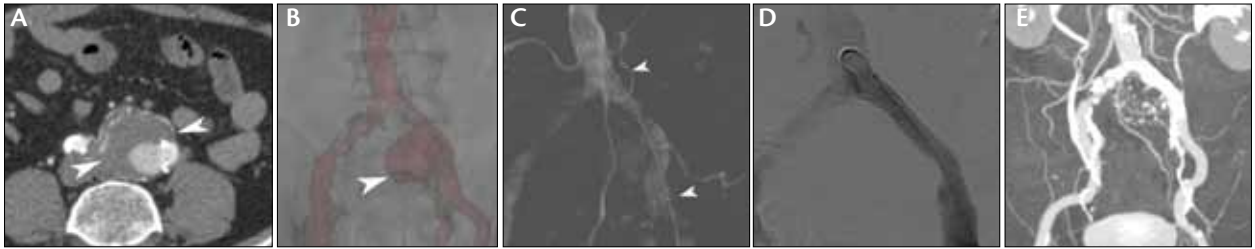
Axial CT image (A) showing an aneurysm of the left CIA (arrowheads). Note interruption of the calcific rim medially, indicative of a penetrating ulcer. Fusion image of live fluoroscopy and imported CT data showing the aneurysm (arrowhead) (B). Roadmap image showing position of the stent (arrowheads) between the aortic and left iliac bifurcation (C). Control angiography showing exclusion of the aneurysm and patency of the left internal iliac artery (D). MIP image of CT angiography performed 9 months after the stent placement showing complete exclusion of the aneurysm (E).
